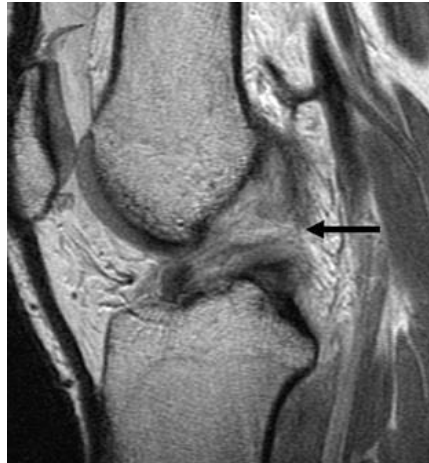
Sagittal MRI image shows an acute complete tear in the anterior cruciate ligament. High signal with discontinuity of the fibers (black arrow).
